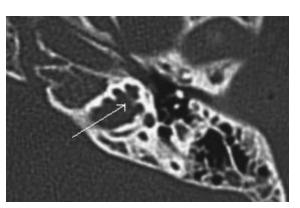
Axial CT image of the left petrous temporal bone.
